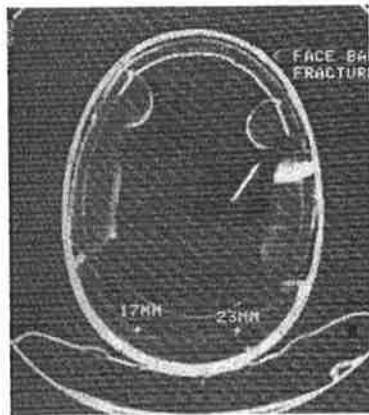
Axial CT scan of helmet.
